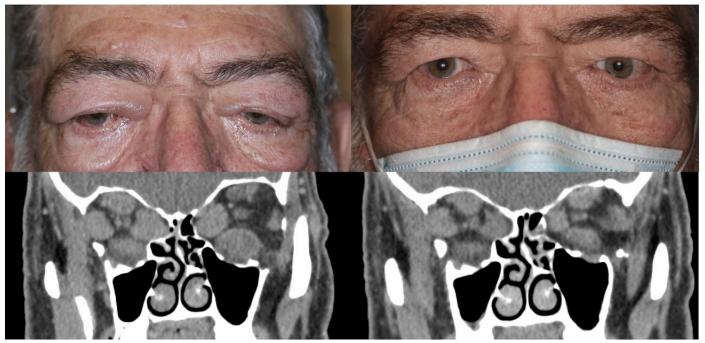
Left column: External photograph and computed tomography (CT) of the orbit pre-tocilizumab treatment. Note significant swelling in the periorbital area with fullness in all four eyelids and conjunctival hyperemia. On CT, note significant extraocular rectus muscle enlargement. Right column: External photograph and CT of the orbits 3 months following intravenous tocilizumab shows significant improvement.
